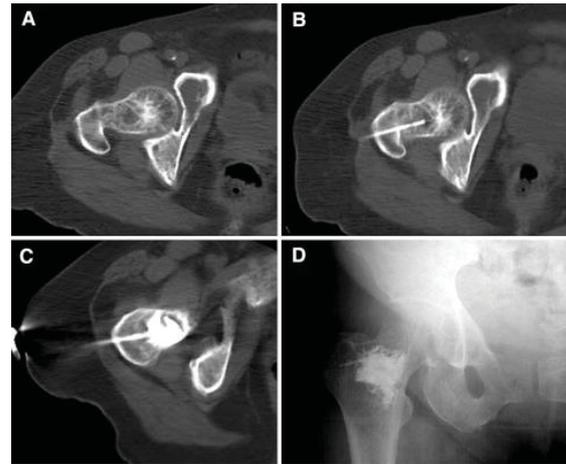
A) CT scan shows lytic lesion in the femoral neck B) Electrode in place C) CT scan during cementation D) Image after ablation and cementation [6]
